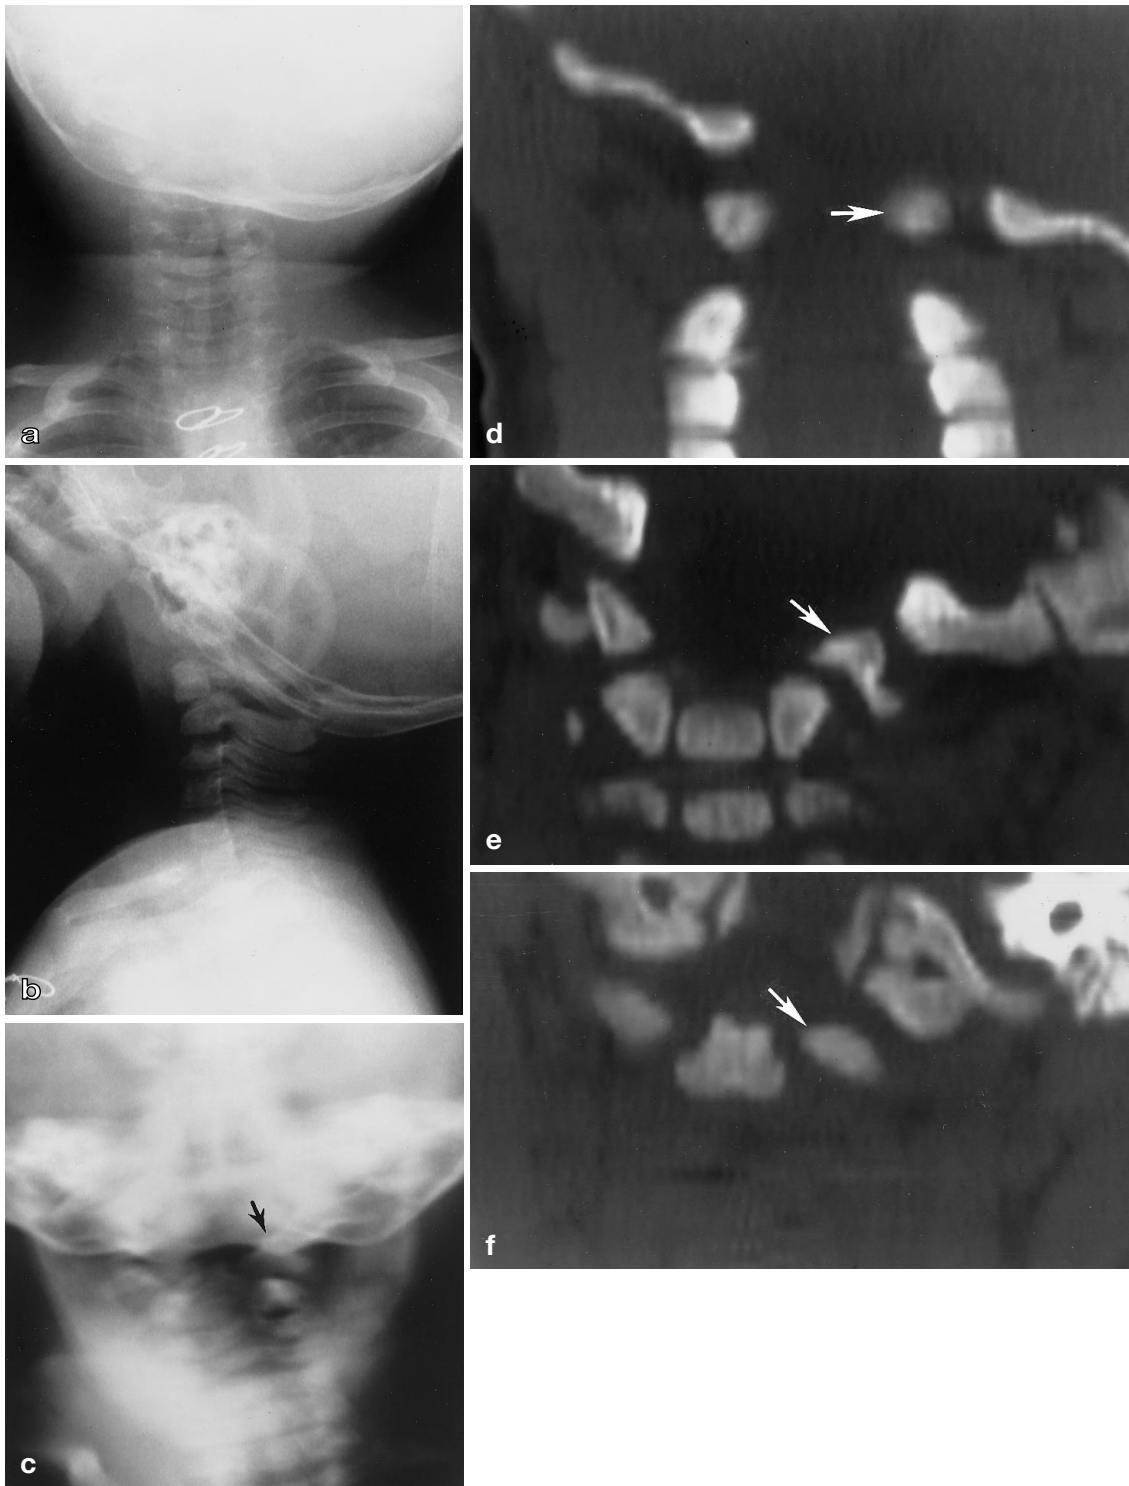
a The occiput is tilted to the left. b The occiput remained extended on C1, even when attempts were made to flex the cervical spine. c On the autotomogram, the left lateral mass of C1 appears to project above the foramen magnum (*black arrow*). d On this coronal reformatted image from the CT data set through the posterior foramen magnum, the left posterior neural arch of C1
